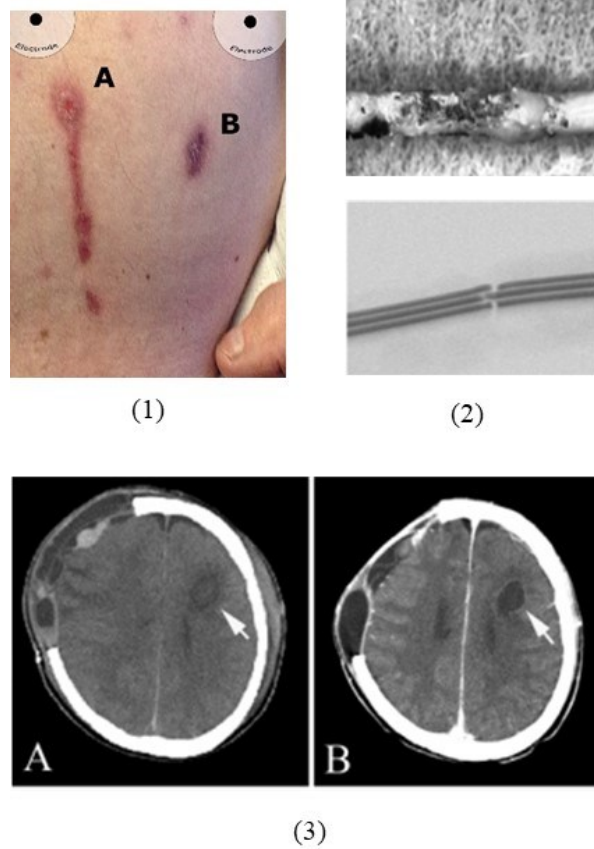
Examples of the damages due to RF heating during MRI. (1) shows the skin burn caused by an MRI-conditional metal device. (2) shows the overheated and melted medical device in the brain, and (3) shows the resulting thermal brain injury.
